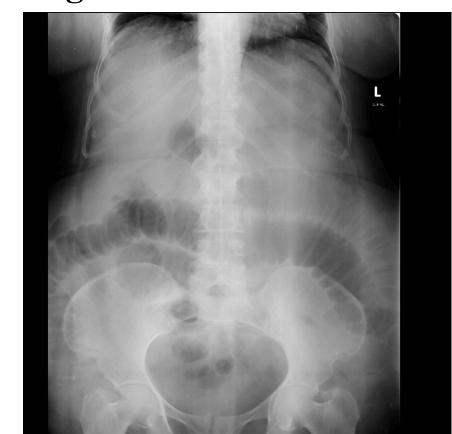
Xray showing dilated bowel loops
